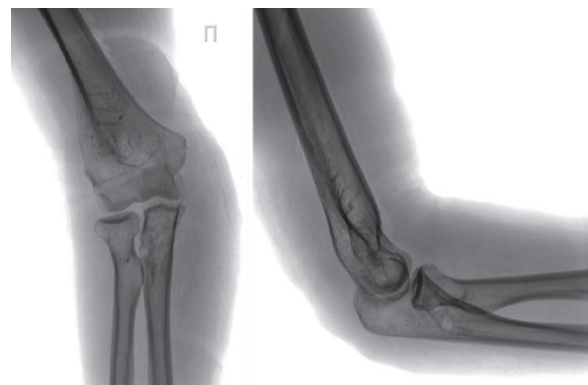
Postoperative radiographs of the elbow joint in two projections
